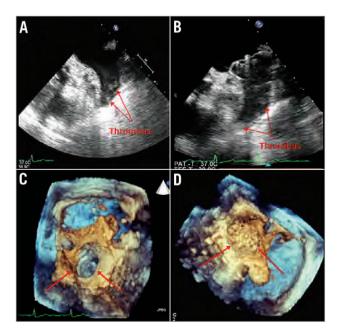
Patient 1. A) Transoesophageal echocardiographic (TEE) view of the left atrial appendage (LAA) thrombus prior to implantation. B) WATCHMAN $^{\text{TM}}$ device after implantation with remaining thrombus in the distal LAA. C) 3D-TEE view of the LAA ostium with thrombus visible within the LAA. D) 3D-TEE after implantation of the WATCHMAN $^{\text{TM}}$ device.
